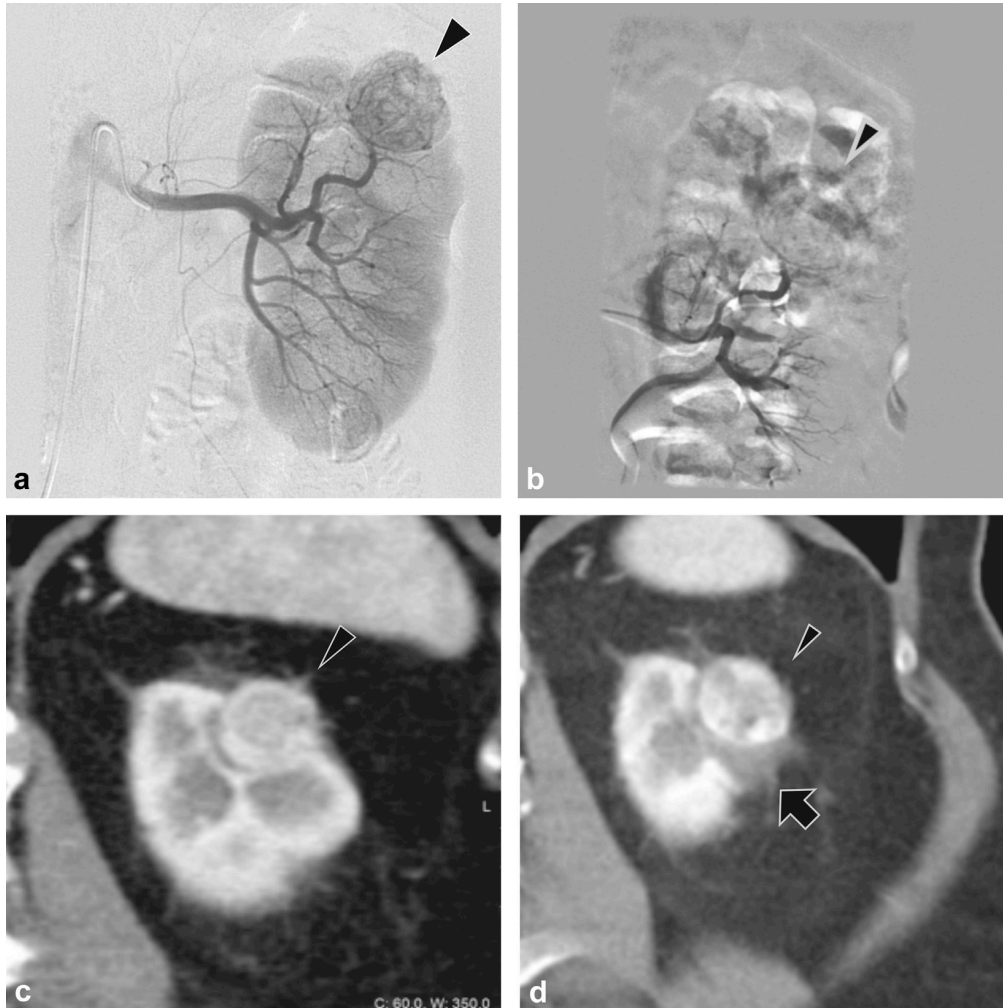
Images of RCC treated by TAE in patient 5. (a) Subtraction angiography image obtained after selective catheterization of the left renal artery showed contrast-filled intratumoral vessels (arrowhead) before TAE. (b) Subtraction angiography image obtained during TAE showed no contrast-filled vessels in the tumor (arrowhead) owing to ongoing embolization. (c) CT image obtained before TAE showed contrast enhancement in RCC (arrowhead). (d) CT image obtained 4 weeks after TAE showed persistent contrast enhancement in RCC (arrowhead). Infarcted renal tissue (arrow) is adjacent to the treated tumor.
